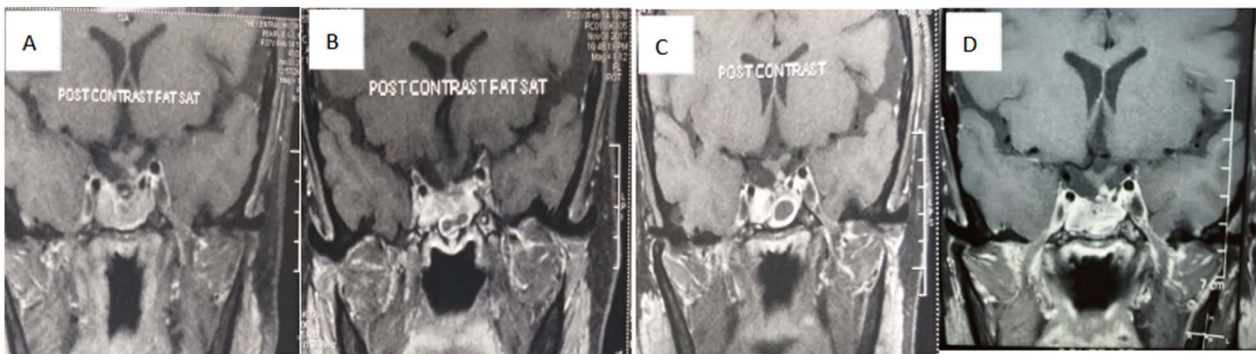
Changes in CE-MRI tumour control with the disease
